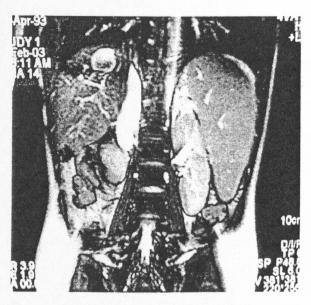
The cyst in the right liver lobe communicating with the biliary system is documented in this coronal T2-weighted MR image.
